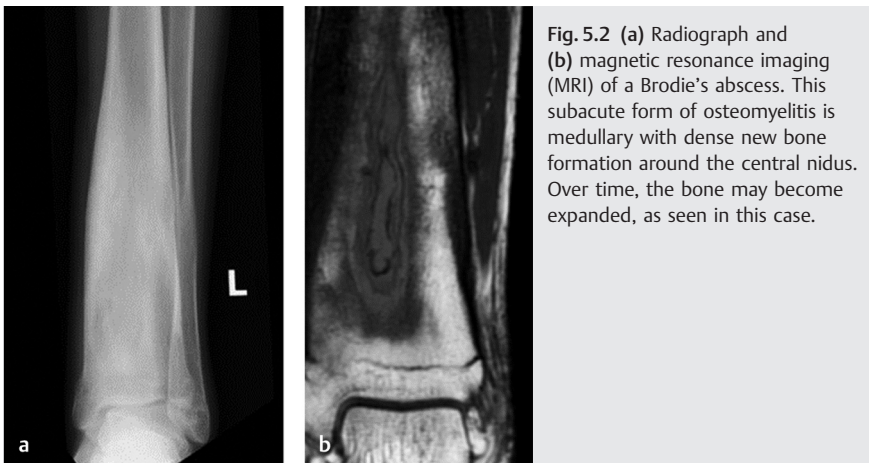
(a) Radiograph and (b) magnetic resonance imaging (MRI) of a Brodie's abscess. This subacute form of osteomyelitis is medullary with dense new bone formation around the central nidus. Over time, the bone may become expanded, as seen in this case.
